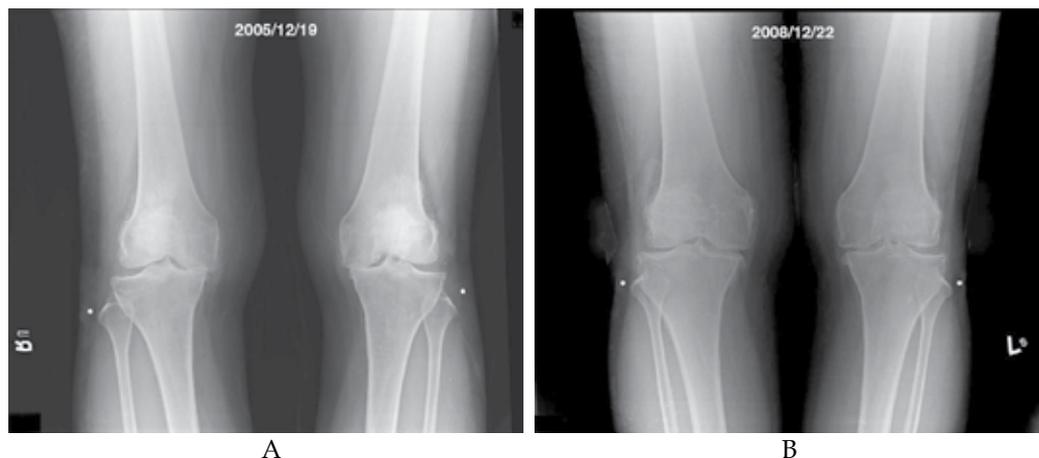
Another example of reversal of natural course by ACRFP: A, AP standing view of a 58 years old female patient having bilateral grade IV OA with subluxation of medial femoral condyle; B, three years after ACRFP, obvious improvement of the radiographic manifestation could be observed.
